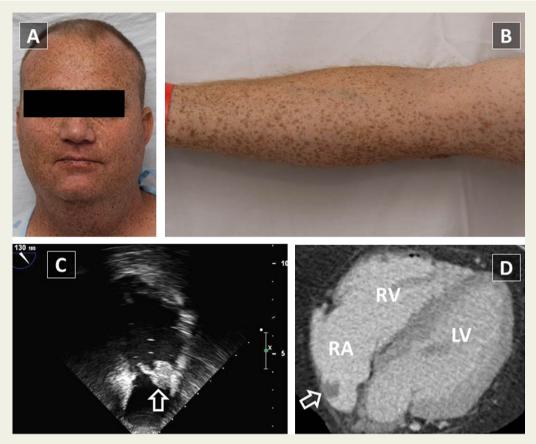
Preoperative evaluation. Panels A and B: skin pigmentation (lentigines). Panel C: transoesophageal echocardiogram showing the right atrial mass (white arrow). Panel D: right atrial mass (white arrow) on a transverse plane of a cardiac computed tomogram.
